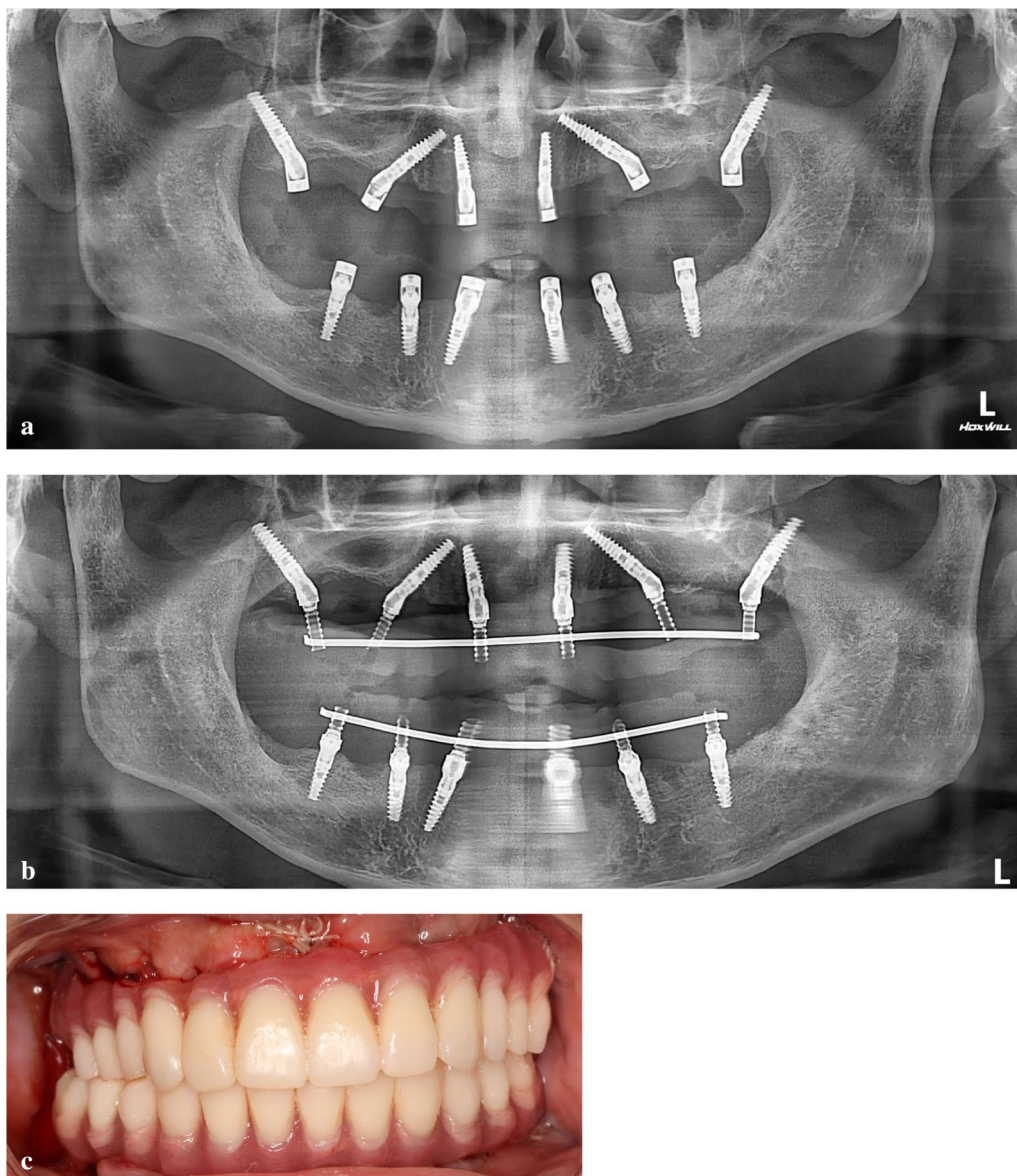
A Panoramic radiograph was taken immediately after implant placement. B Panoramic radiograph was taken after transfer copings splinted. C Occlusal view
